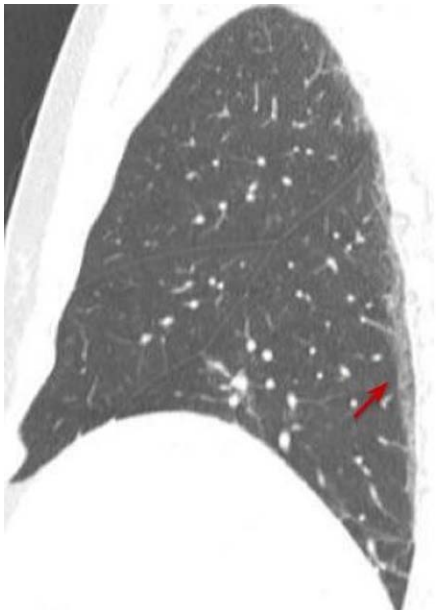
A sagittal CT scan with lung window settings showing a dependent opacity in the posterior region of the right lower lobe (arrow).
